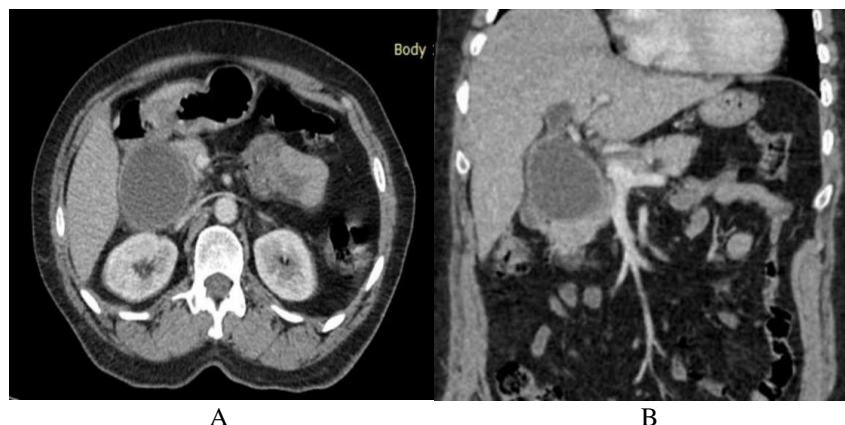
(A-B): Axial and coronal sections of injected abdominal CT showing a cystic dilation of the main bile duct, exerting a slight mass effect on the duodenal and pancreatic parenchyma.
